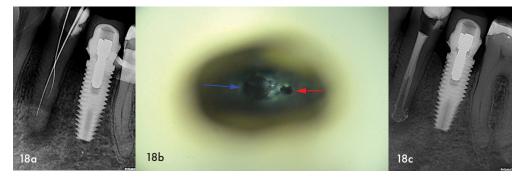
(a) Periapical radiograph showing the lingual canal detection in the midroot level of a mandibular left first premolar; (b) the orifice of the second canal was located under magnification (19X) after a dentine ledge was removed with an ultrasonic tip. Note the main buccal canal (blue arrow) and the located orifice of the lingual canal (red arrow); (c) postoperative obturation result
